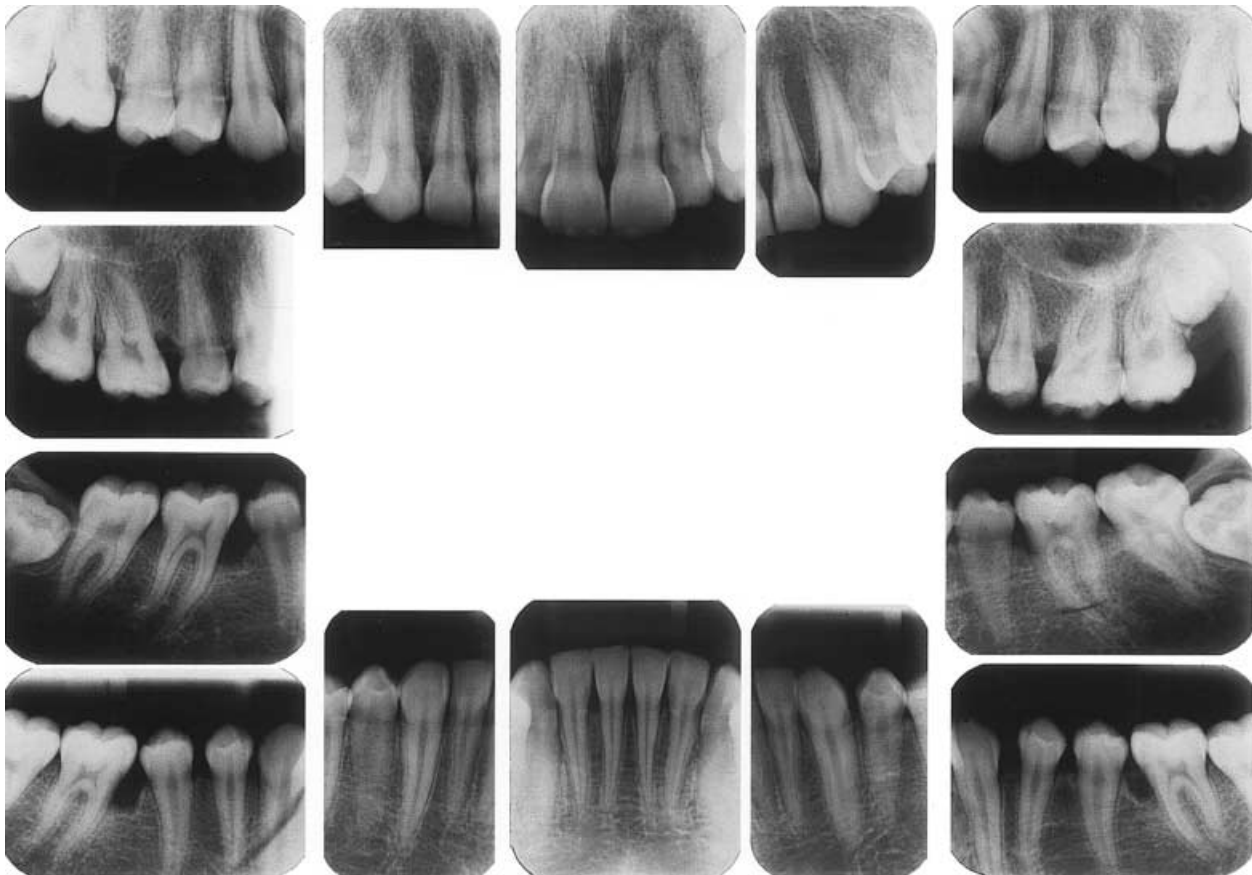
A 14-year-old Moroccan boy with localized aggressive periodontitis. On full-mouth intraoral radiographs bone loss was visible at all permanent first molars and the upper left central and lateral incisors.
